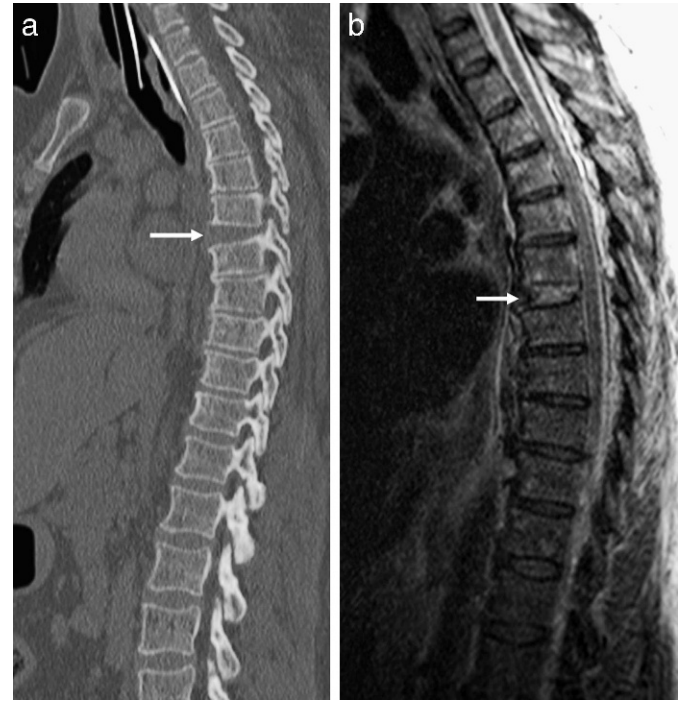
Hyperextension injury. (a) Sagittal CT demonstrates widening of the anterior T6–T7 disk space (arrow). (b) Sagittal T2-weighted image demonstrates widening of the disk space and edema within the intervertebral disk (arrow).
